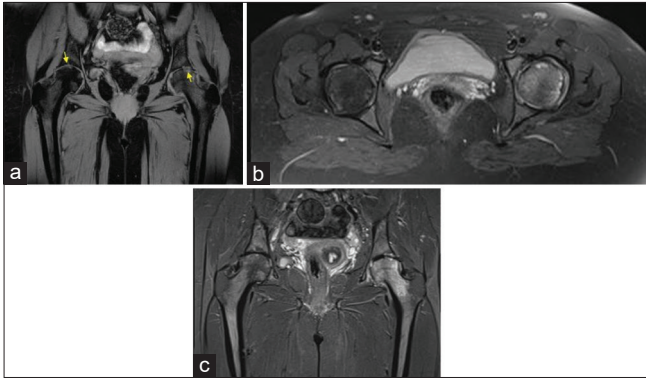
Magnetic resonance imaging findings. (a) On MR T1 FSE coronal. (b) PDFS transverse. (c) T1 STIR coronal
